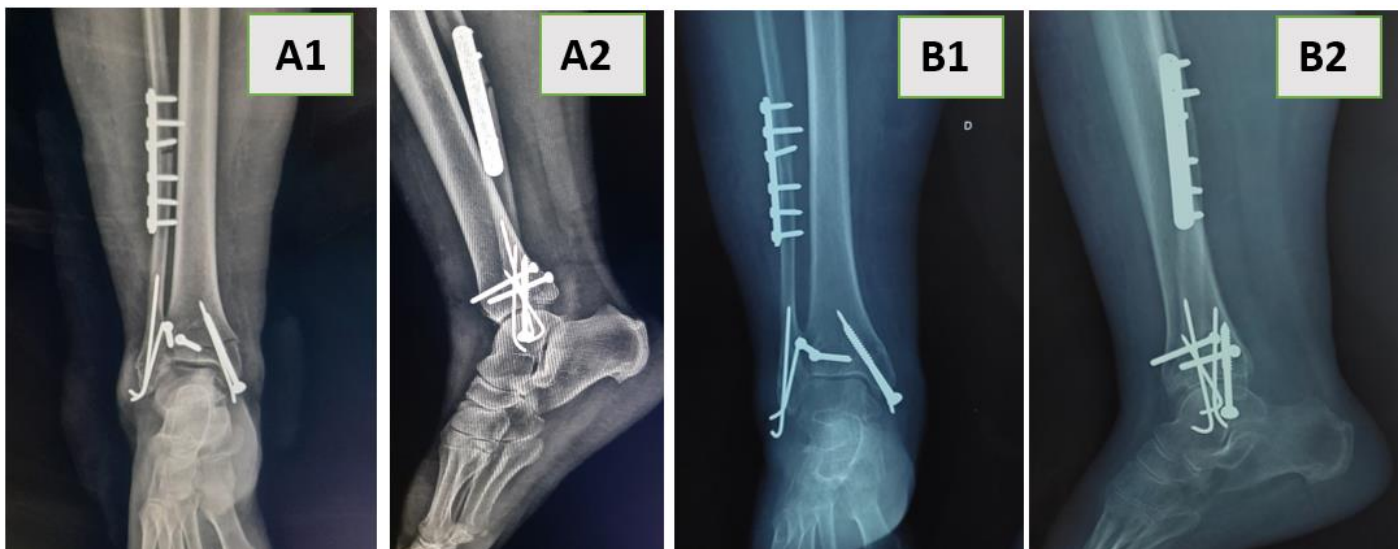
Immediate postoperative radiographic control (A1, A2) and after 3 months showing fracture consolidation (B1, B2).
